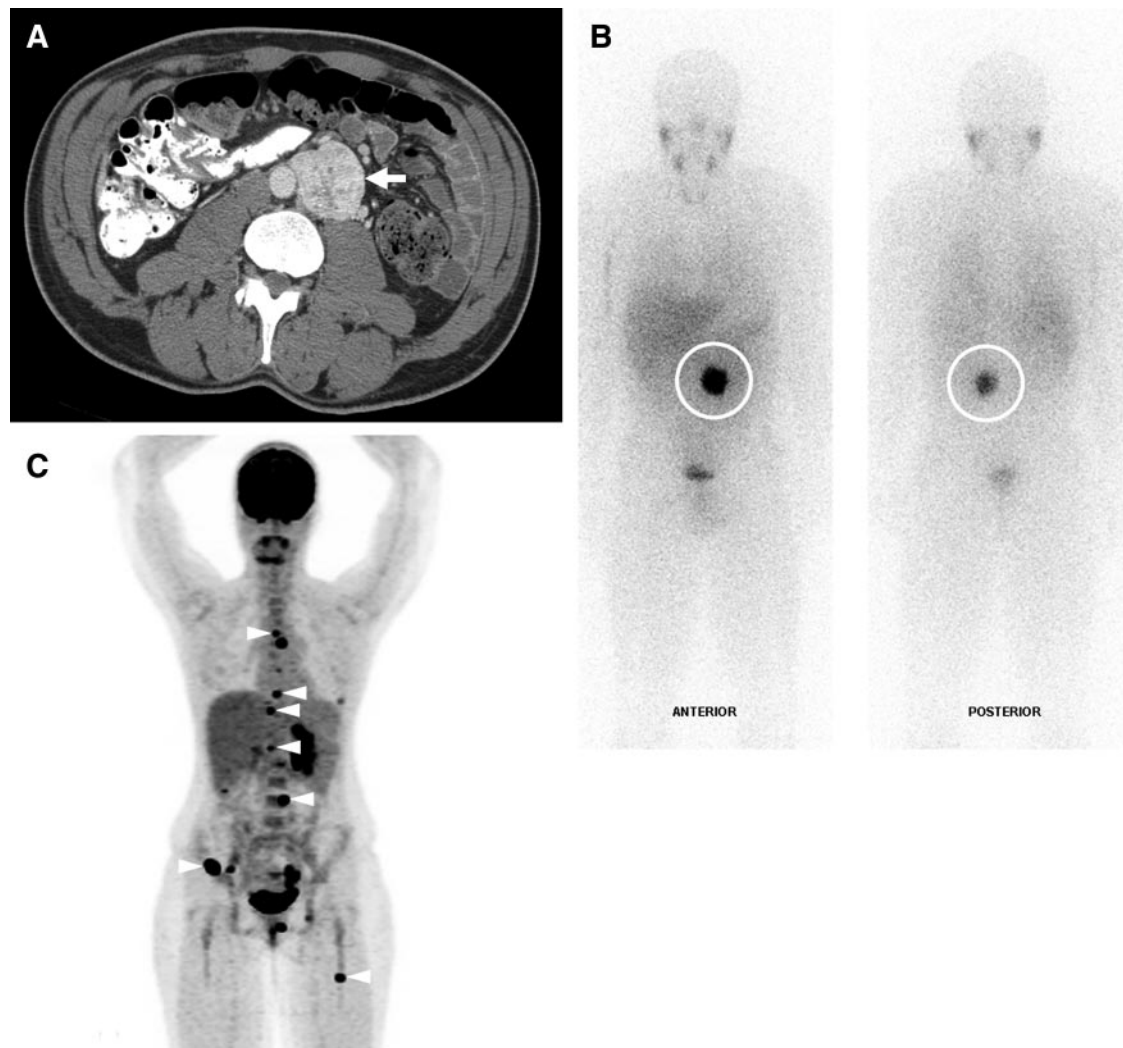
PGL. A, Axial CT after contrast in a patient with symptoms of catecholamine excess and a noradrenergic biochemical profile. A PGL (arrow) is identified in a paraaortic location between the left renal artery and the origin of the inferior mesenteric artery in the region of the organ of Zuckerkandl. B, MIBG scan in the same patient, 24 h after the administration of [^{123}I]MIBG, demonstrating intense uptake in the tumor. C, [^{18}F]FDG PET scan in a patient with metastatic PGL and an *SDHB* mutation. Bony metastatic disease (arrowheads) predominates.
